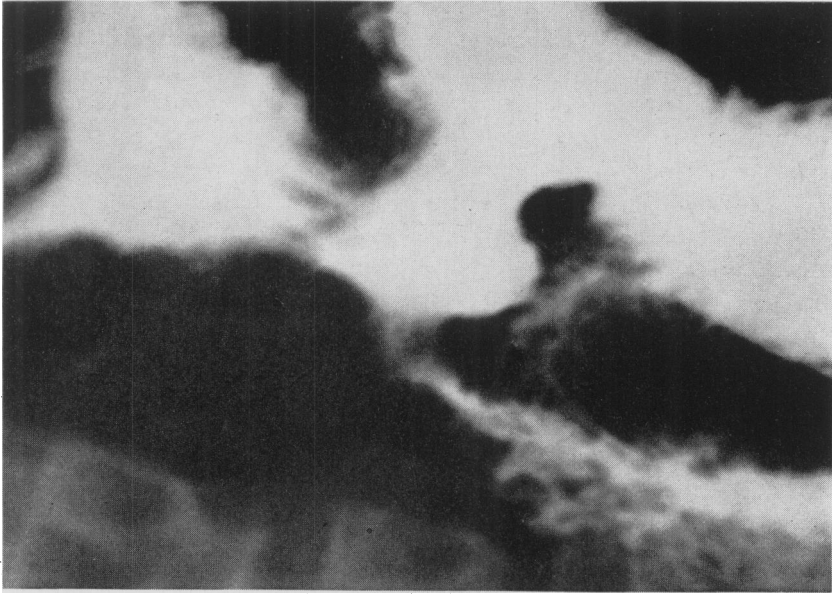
X-ray film showing definite decrease in gastrojejunal ulcer crater 25 days after transthoracic vagotomy.
